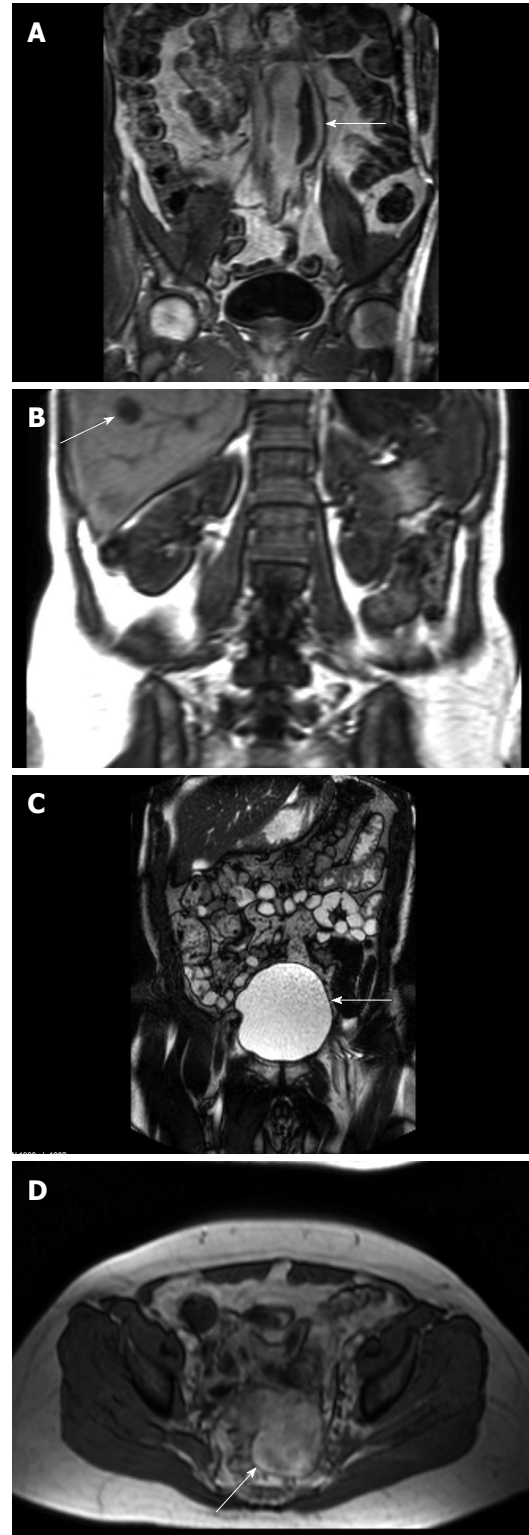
Incidental findings at MRI-enterography. A: Abdominal aortic aneurysm (arrow). CT scan confirmed the aneurysm and ruled out rupture; B: Atypical hepatic hemangioma (arrow). The results of ultrasound-guided biopsy were benign; C: Large bladder leading to diagnostic work-up and diagnosis of prostate cancer (arrow); D: A lesion with a diameter of 6 cm in the small pelvis (arrow) was confirmed with transvaginal ultrasound. Surgery showed a torquated leiomyoma in the top of the uterus.
